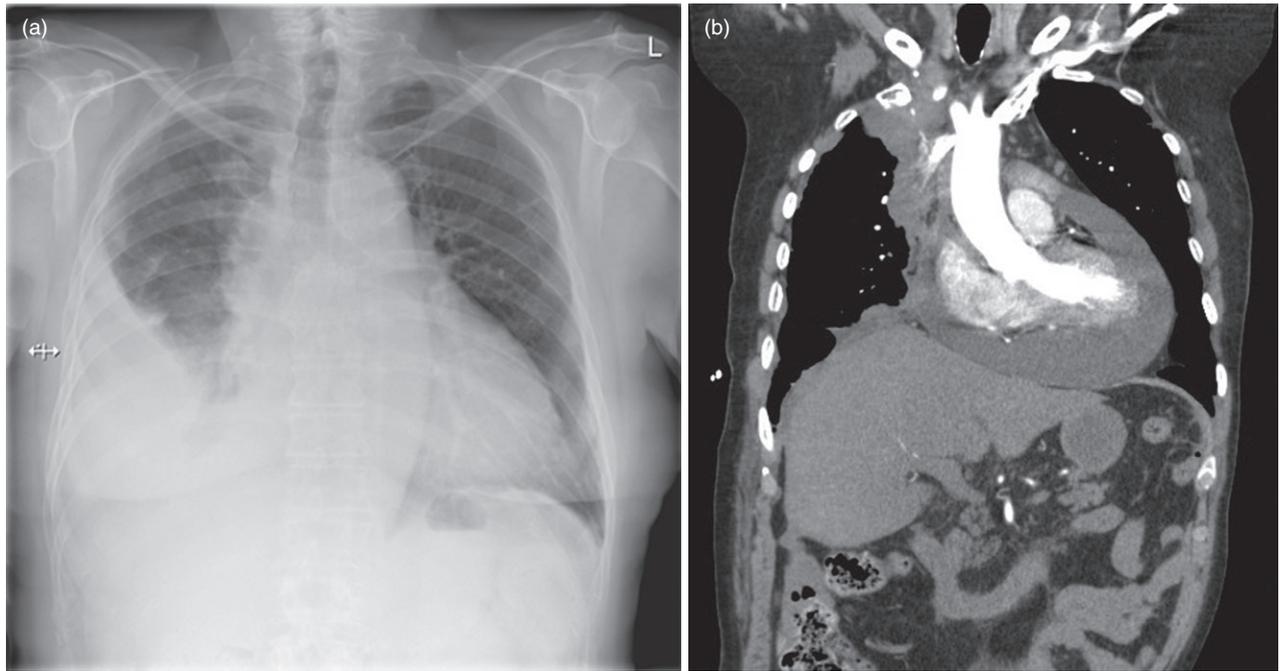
(a) Chest X-ray of a patient with malignant mesothelioma who presented with worsening breathlessness. Therapeutic pleural drainage produced only partial relief. (b) Subsequent computed tomography thorax (coronal view) revealed a large pericardial effusion but no pleural effusion. Echocardiogram confirmed pericardial tamponade. The patient’s breathlessness significantly improved following pericardiocentesis.
